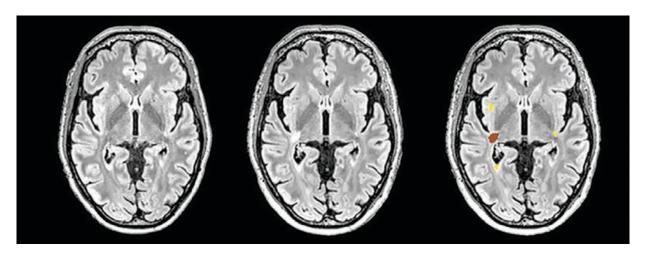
Detection of new MS lesions using the nnU-Net CNN on 3D-FLAIR sequences. Lesions identified at baseline are marked in yellow, while potential new lesions that may develop are marked in brown.
